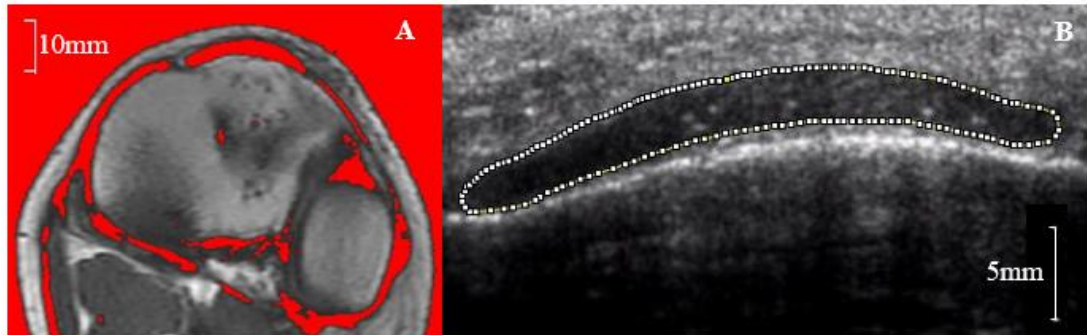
Axial MRI image showing the automatically outlined PT CSA (A) and the corresponding axial US image showing the manually outlined PT CSA (B) using imageJ software (ImageJ 1.45; National Institutes of Health, Bethesda, MD, USA).
